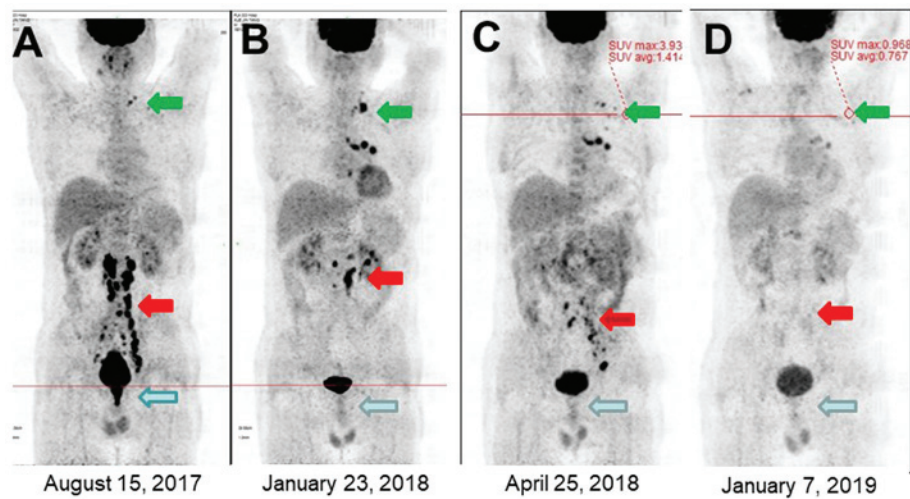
The course of advanced rectal cancer during treatment with the ‘observe and wait’ method. (A) Primary rectal tumor (green arrow), retroperitoneal metastatic (red arrow) and subclavian lymph nodes (cyan arrow) before treatment were identified using PET-CT examination. (B) The primary rectal tumor was completely shrunk and the retroperitoneal lymph node region remained partially residual. However, the number of unirradiated lesions in the subclavian lymph nodes increased following first radiotherapy. (C) The primary lesion disappeared and the subclavian lymph nodes were shrunk following radiotherapy. However, some lesions were relapsed. (D) The enlarged subclavian and retroperitoneal lymph nodes disappeared, and the primary rectal cancer lesion was completely relieved without recurrence. PET-CT, positron emission tomography/computed tomography.
